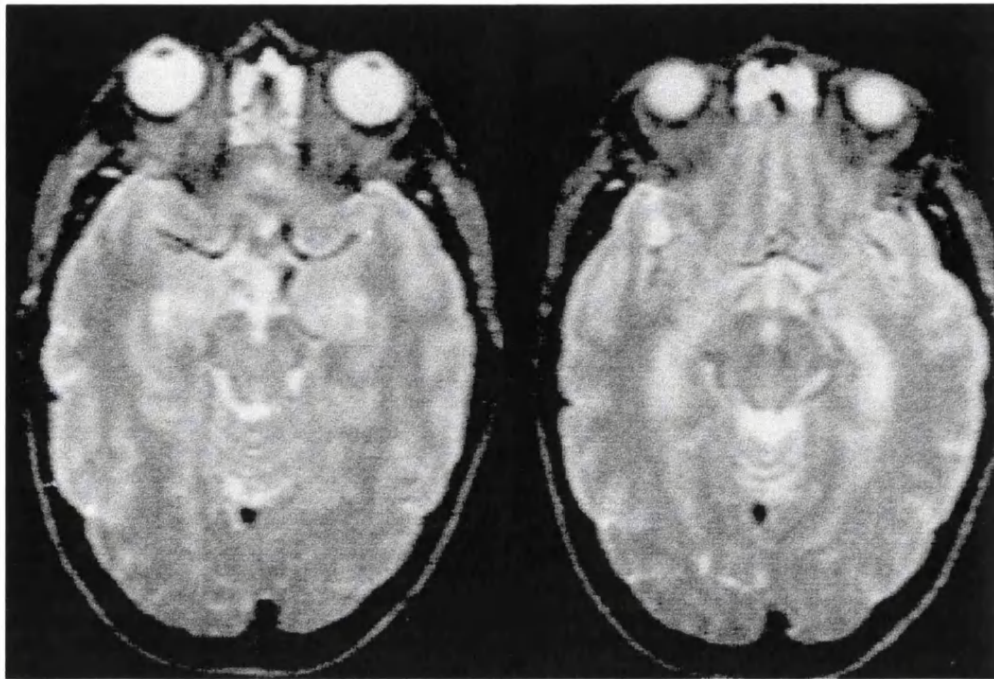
Axial T2-weighted images obtained during status in 1991. An abnormally high signal is visible in the mesio-temporal region bilaterally.
